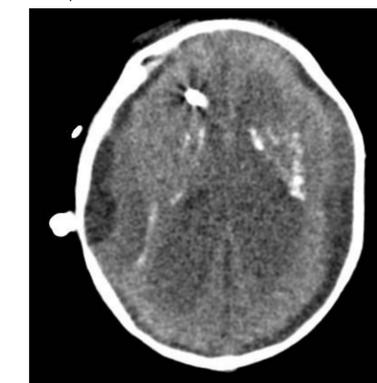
CT imaging shows subependymal calcifications
